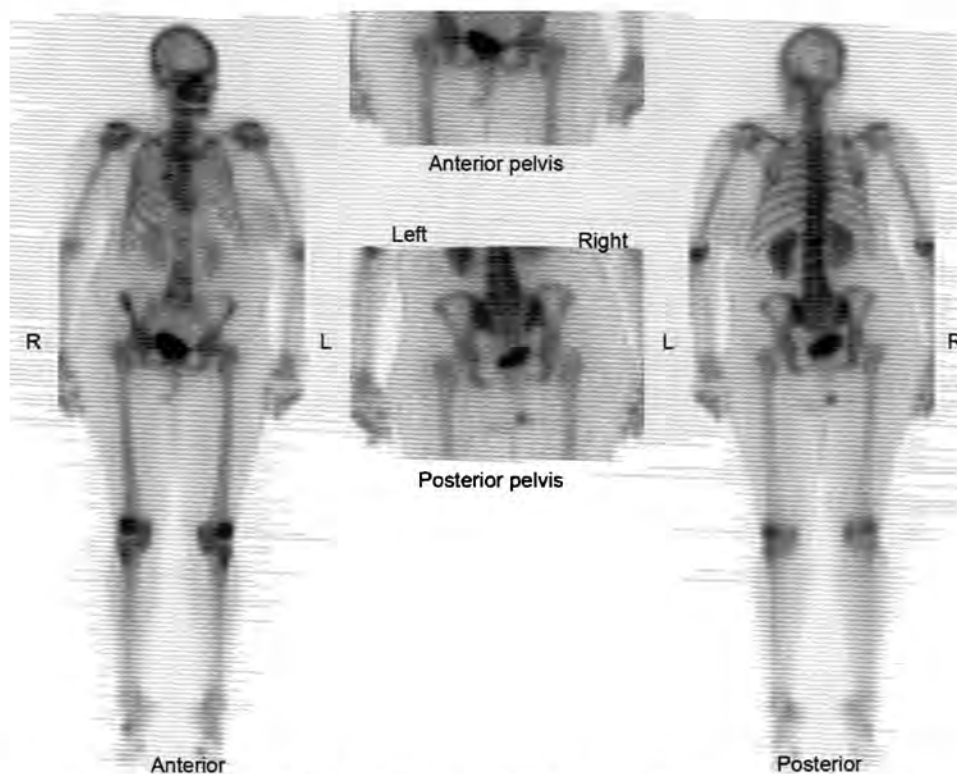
Whole body ^{99m}Tc -Methyl diphosphonate (MDP) images demonstrate focal radiotracer uptake at the tip of the central line in the right parasternal region. No abnormal uptake in the right iliac crest or elsewhere.
